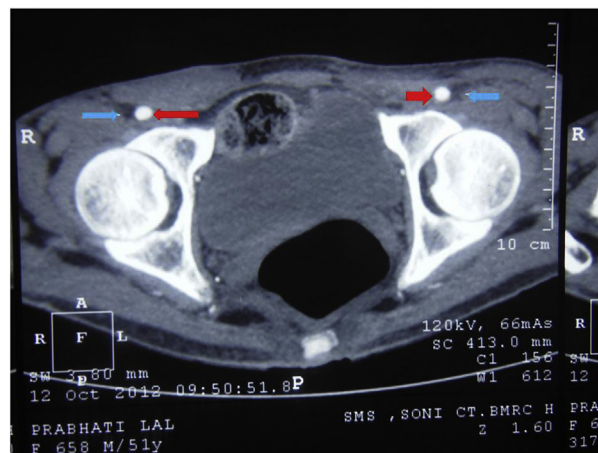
CT angiography showing bilateral transposition of femoral vessels. Red arrows showing femoral artery and blue arrow femoral veins.
